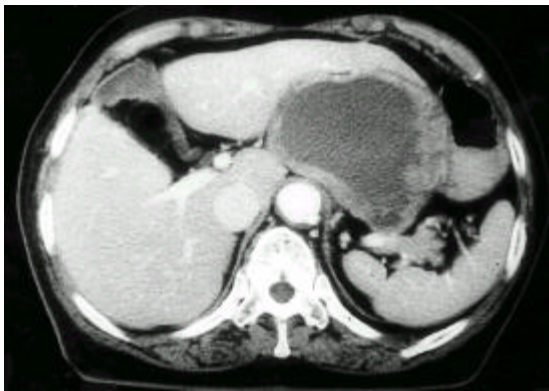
Abdominal CT scan showed a 12x8x8 cm-sized heterogeneous cystic mass in the left upper quadrant of the abdomen. There was marked displacement of the stomach to posterior and inferior side.
